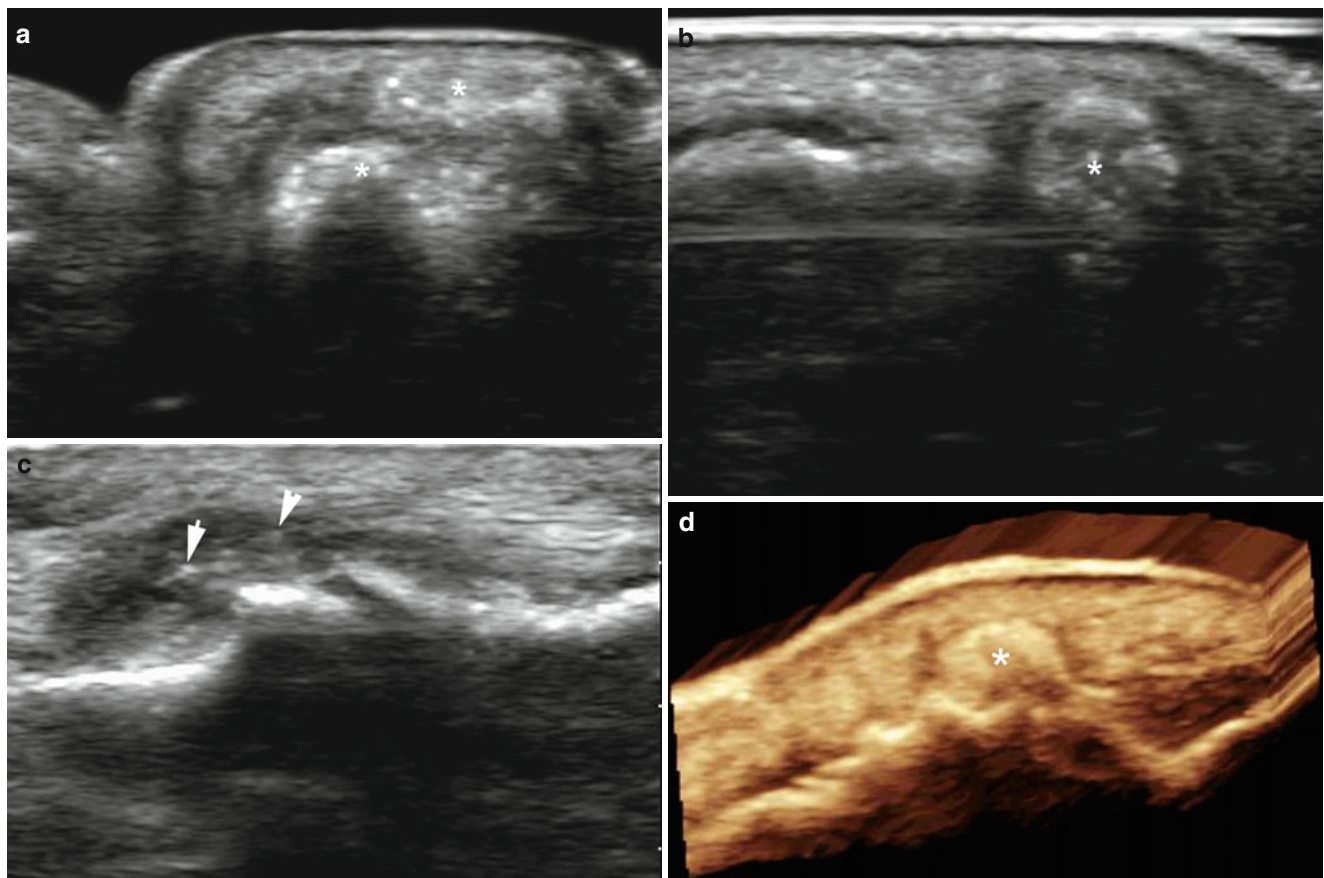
(a–d) Gouty tophi. (a, b) Grey scale ultrasound images (lateral aspect of the left big toe; a transverse view; b longitudinal view) show hyperechoic subcutaneous periarticular deposits (*, gouty tophi). (c) Grey scale ultrasound image (longitudinal view, interphalangeal
